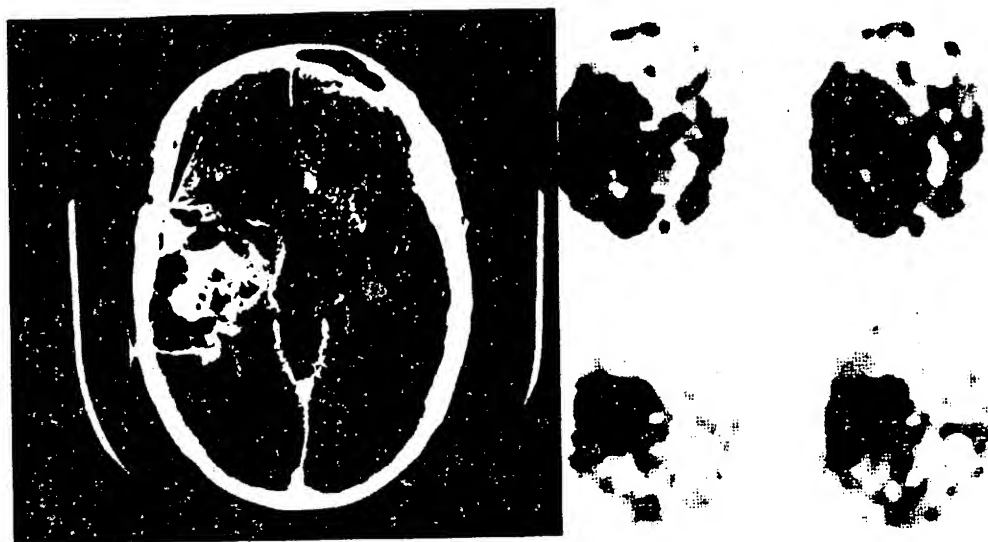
Contrast-enhanced CT (left) and SPECT images (right) of patient 12 obtained 1 (upper) and 18 hours (lower) after intravenous administration of I-123 81C6.
